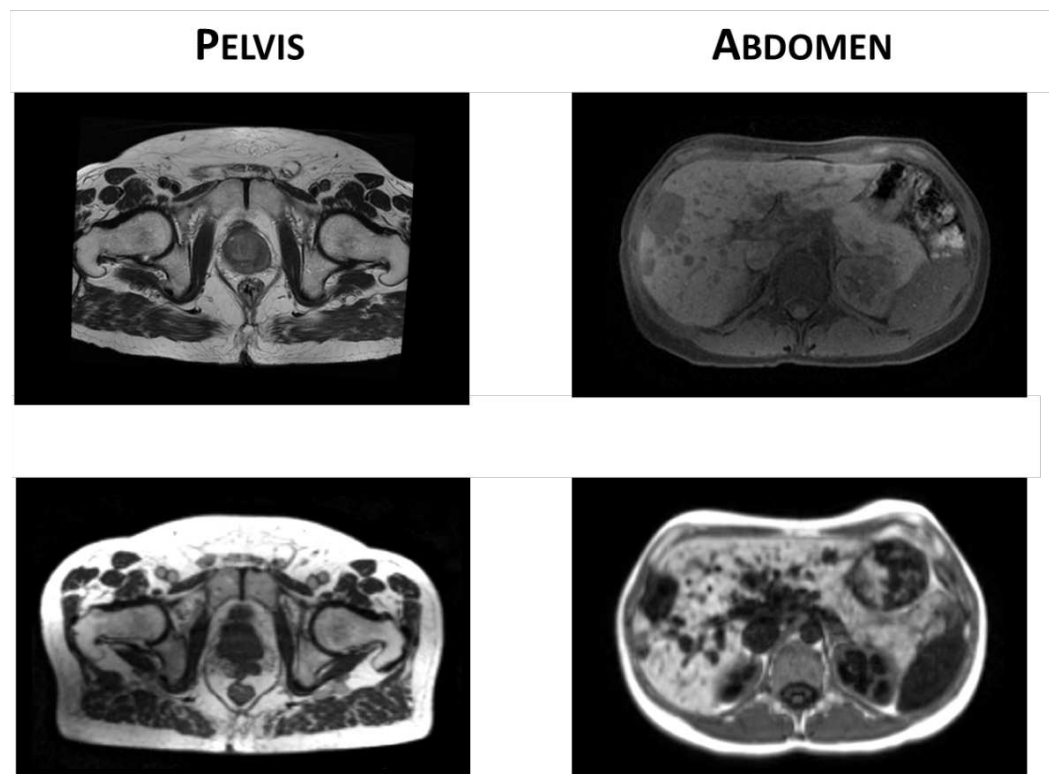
Example of MR images acquired using hybrid machines for a pelvic case (left) and an abdominal case (right): in the upper part two examples of MR images acquired using 1.5 T on-board MR scanner (T2-weighted MRI for pelvis and T1-weighted with fat suppression for the abdomen). In the lower part, two MR images acquired using a 0.35 T MR scanner (TRUFI acquisition for pelvic case and T1 weighted with navigator for the abdominal case)
